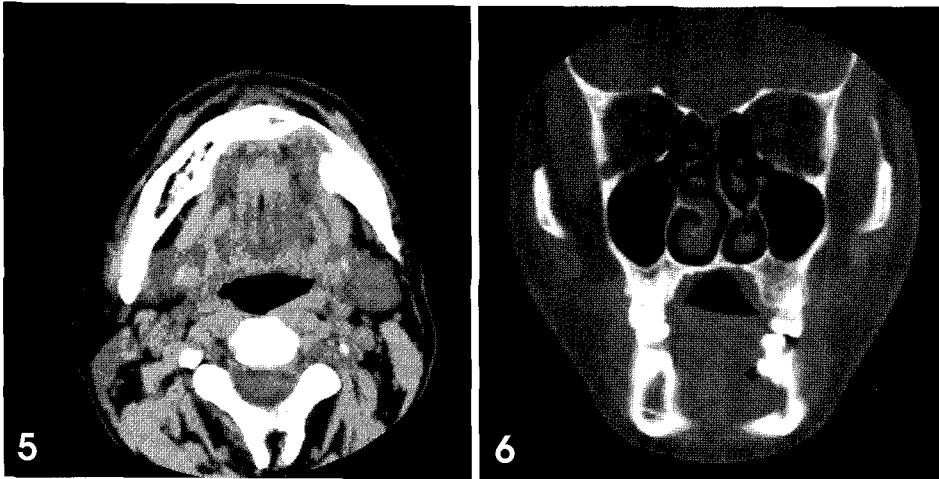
Soft tissue CT axial scan did not show any evidence of pathologic change in the left mandibular bone defect area.
